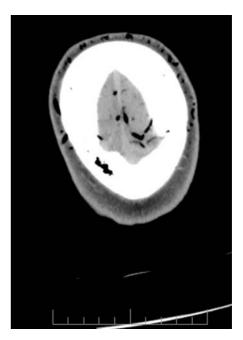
Gas inclusions in cortical veins draining into the superior sagittal sinus seen in a CT slice. This sinus itself again shows hyperattenuation
